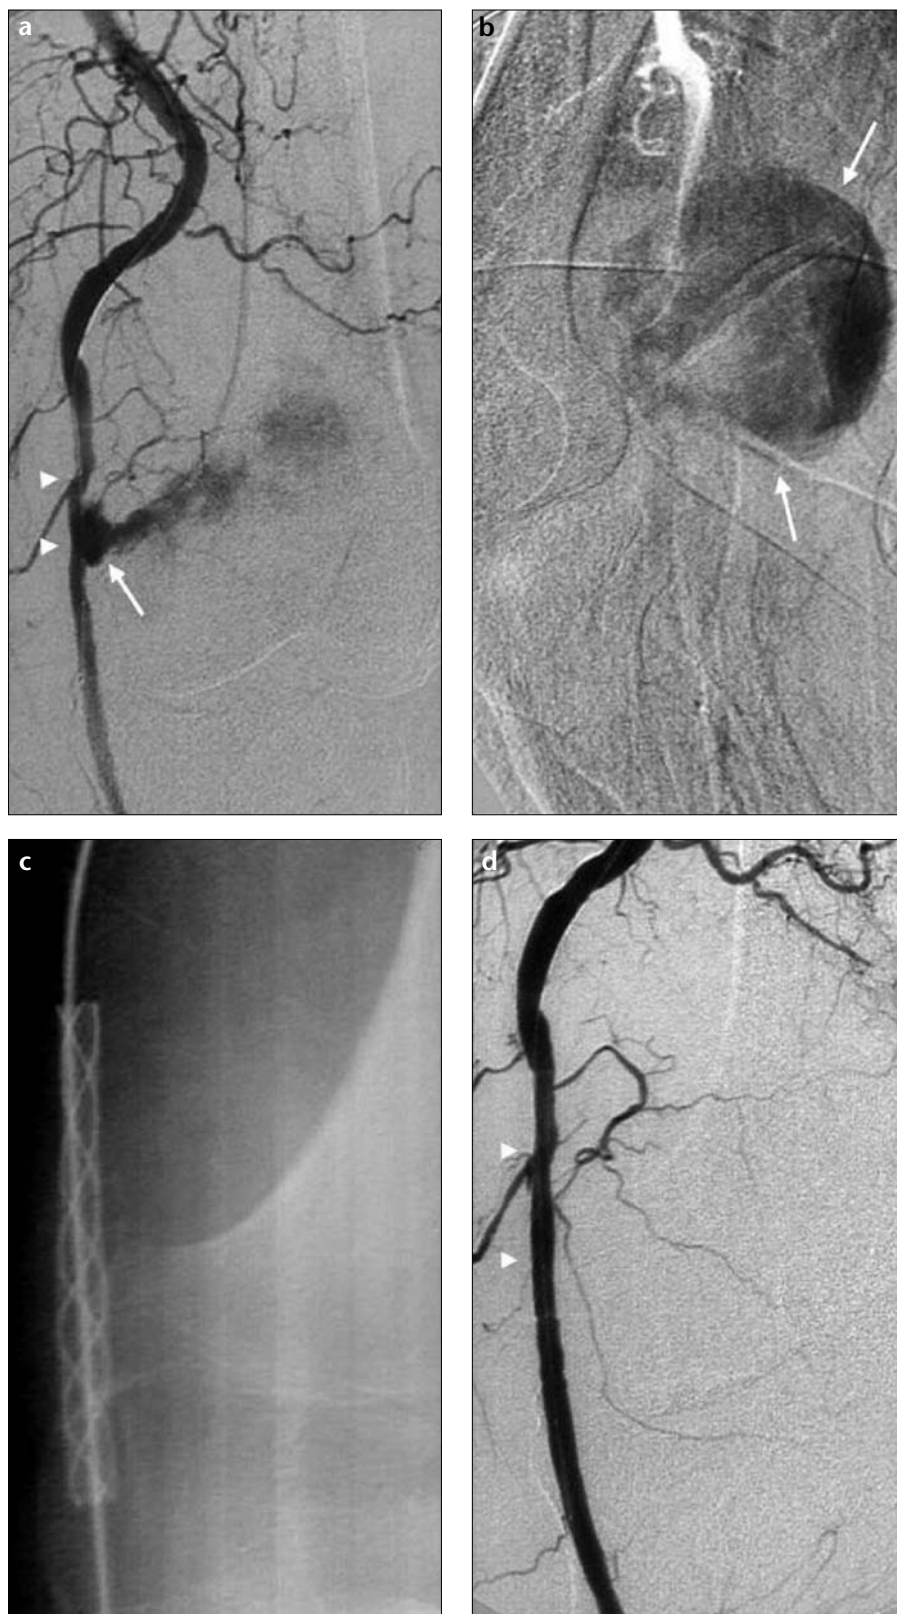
a-d. Selective antegrade injection into the superficial femoral artery shows a pseudoaneurysm of the left popliteal artery in early (a) and late (b) arterial phases (arrows, a and b). Note the arterial irregularity and narrowing due to the compression of the pseudoaneurysm (arrowheads, a). c. Native X-ray shows the implanted stent-graft (Wallgraft, 7 mm in diameter x 40 mm long). d. Angiogram obtained after insertion shows the closure of the pseudoaneurysm. Note the smooth contours of the stented segment (arrowheads).
